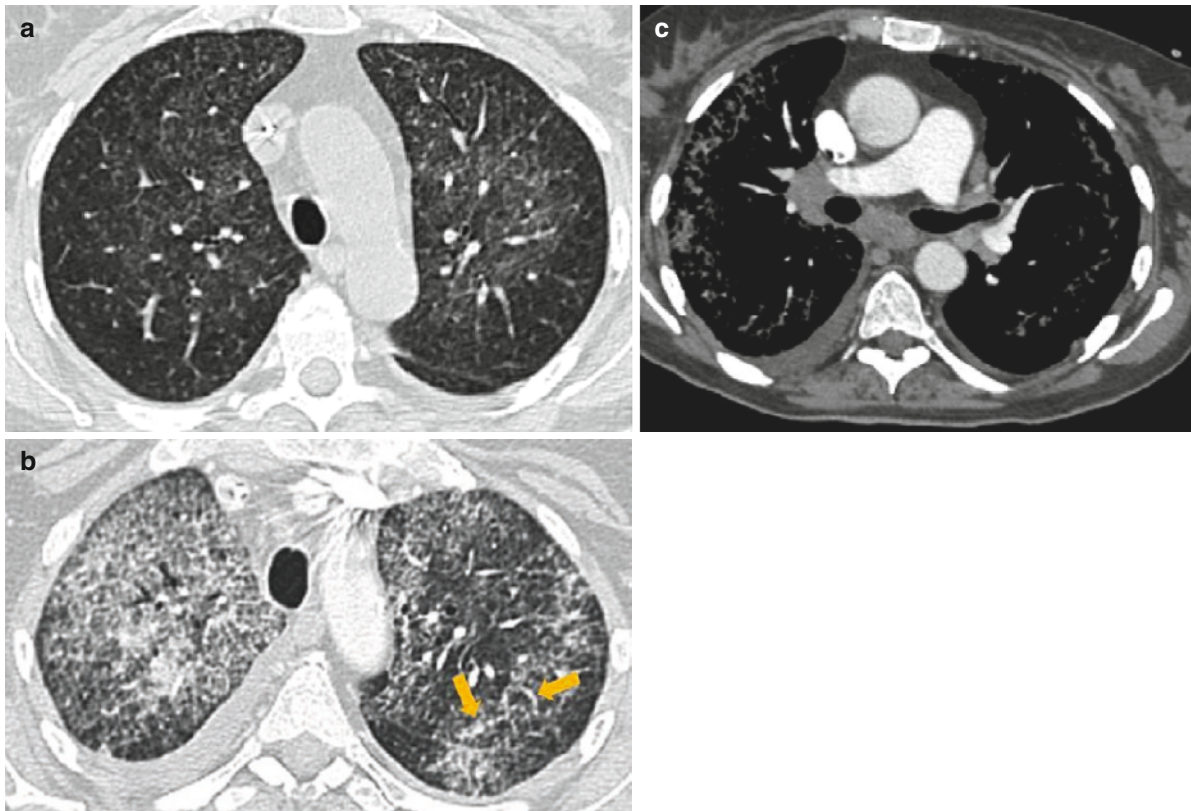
Findings by computed tomography (CT) of the chest. (a) Initial CT scan, thin axial slice with lung window. Subtle ground-glass opacities predominating on the *left side* with tiny superimposed micronodules. Note the sparing of the subpleural area. (b) Follow-up CT scan, thin axial slice with lung window. Note the increased ground-glass opacities with some alveolar consolidation at the level of the apical segment of the right upper
